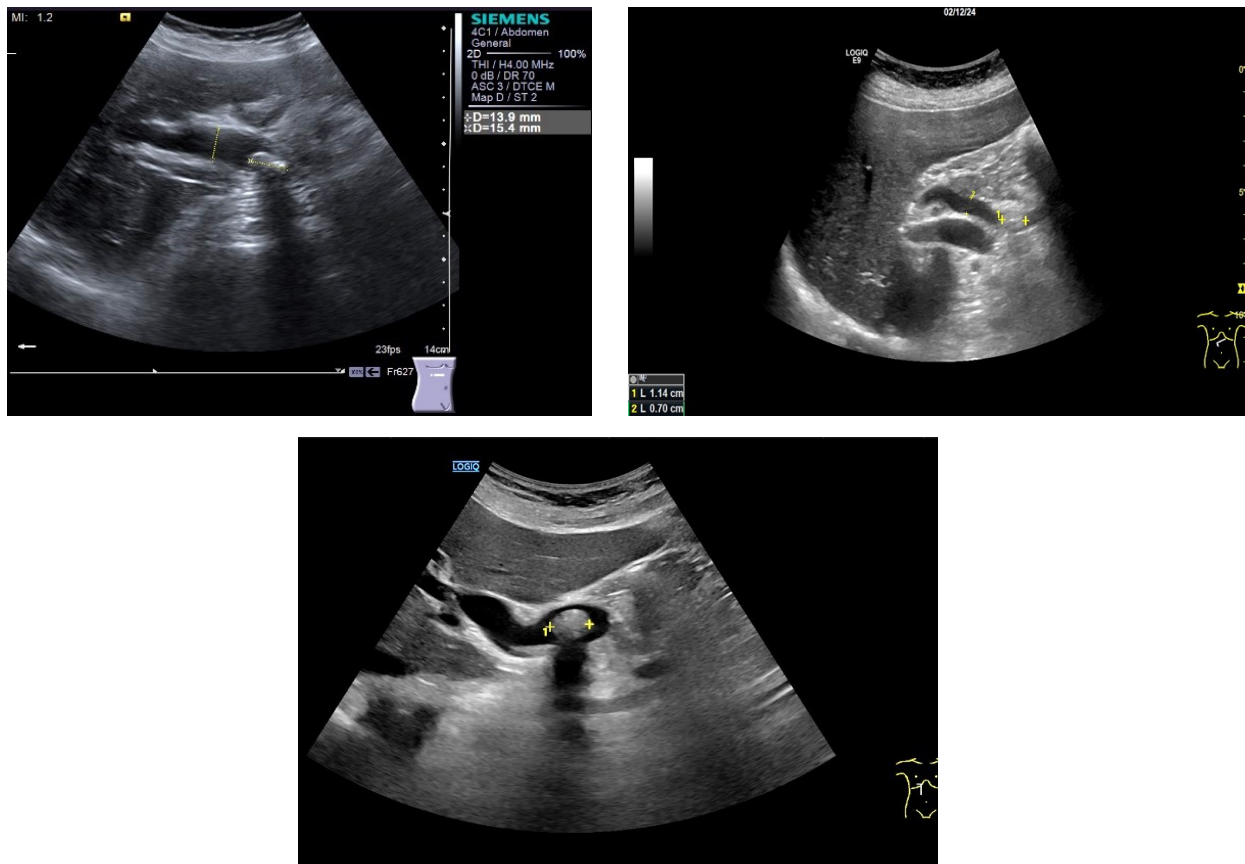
20, 5.21. Ultrasound aspect of dilated main biliary duct with the presence of hyperechoic images with posterior shadowing located inside
